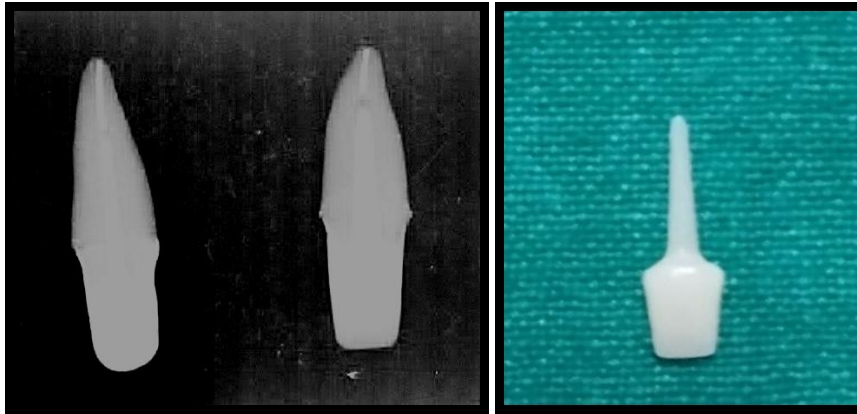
Radiograph of Edelweiss treated samples and Edelweiss post.
